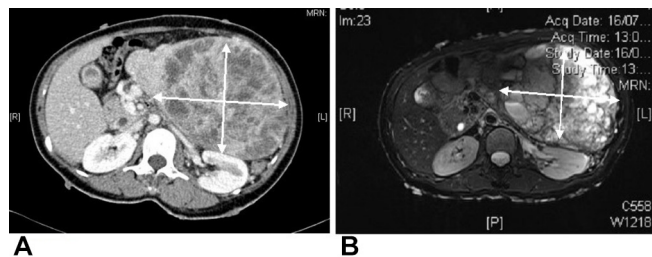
(A) CT abdomen showing a large 18 cm x 20 cm heterogeneous mass with areas of necrosis and mass effect on adjacent structures. (B) MRI abdomen of the same intra-abdominal mass showing hyperintensity on T2.
